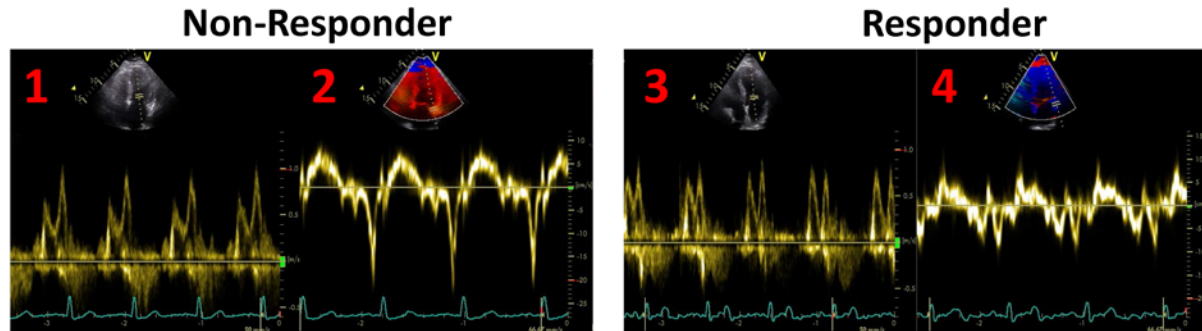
Example of a Doppler mitral inflow velocity tracing for a representative 'responder' at rest (1) and during isometric handgrip echocardiography at 40% MVC (3), along with tissue Doppler tracing from the lateral wall of the same individual during rest (2) and isometric handgrip echocardiography at 40% MVC 'responder' (4) during isometric handgrip at 40% MVC. Change in heart rate (A), mean arterial blood pressure (B) and left ventricular early mitral inflow velocity to
